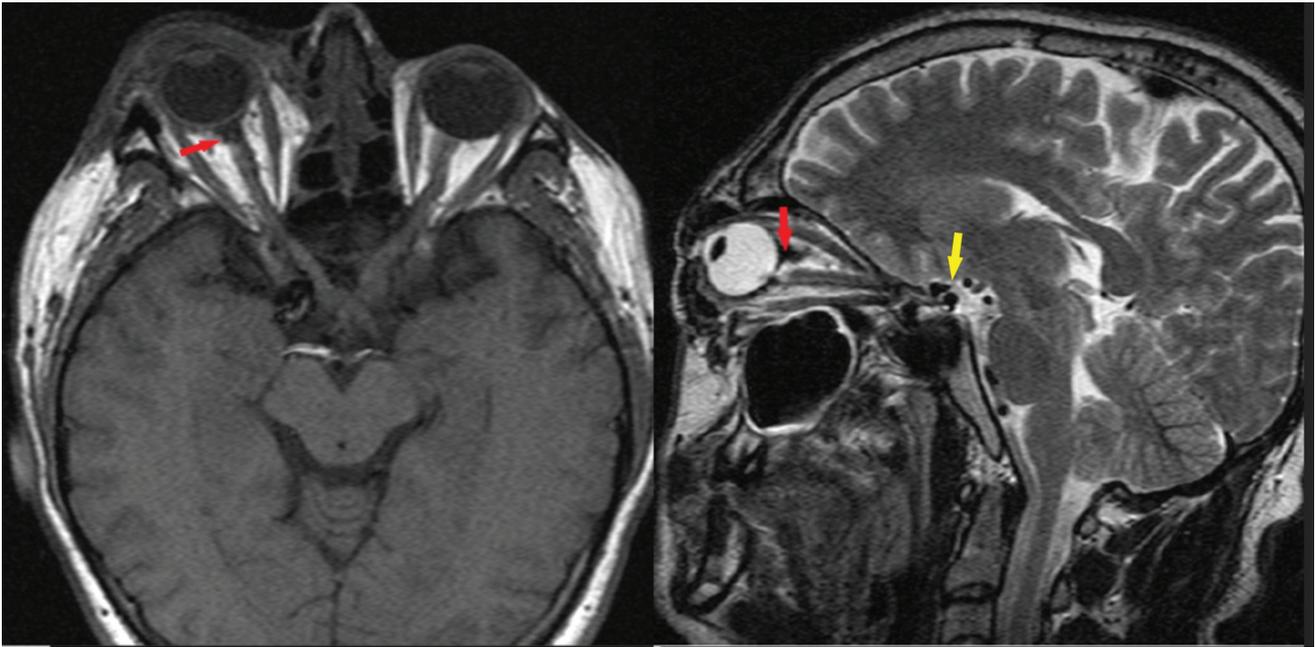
T1-weighted axial MRI and T2-weighted sagittal MRI showing the site of optic nerve avulsion (red arrows) and pneumocephalus (yellow arrow)
